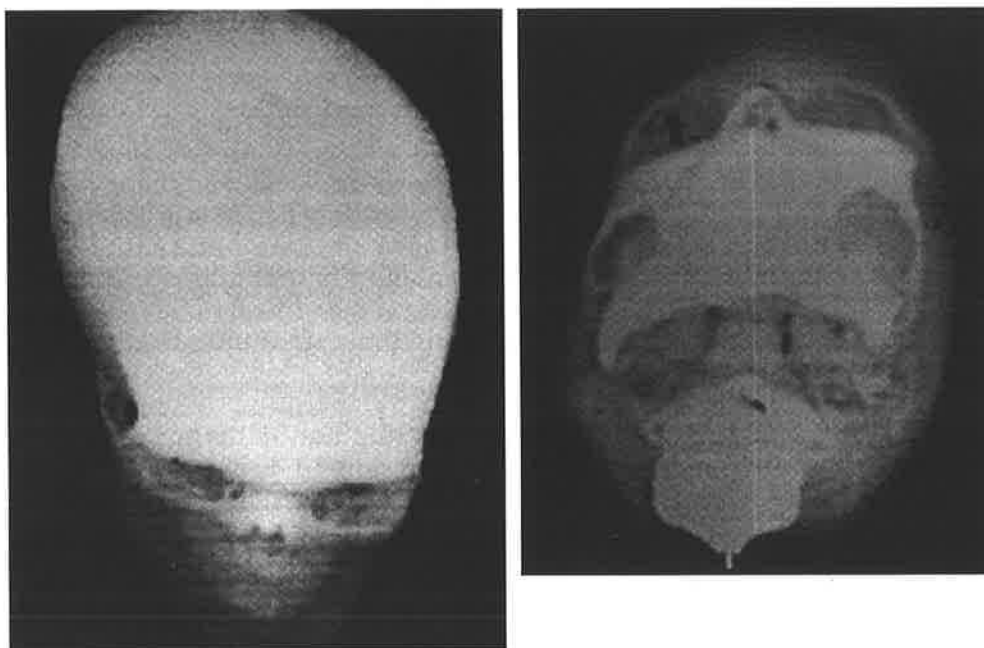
A. Bird's-eye and B. worm's-eye 3-D CT reformats reveal the marked parallelogram plagiocephaly above and the obvious orbitozygomatic asymmetry below.
